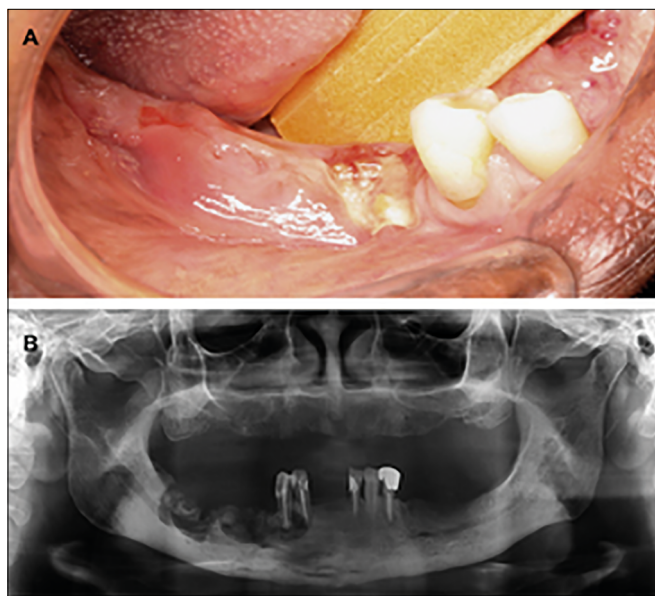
A - MRONJ clinical features showing an asymptomatic area of exposed necrotic bone on the alveolar region of the lower right premolar with no spontaneous bleeding or signs of infection. B - Initial panoramic radiography revealed the presence of diffuse sclerosis and sequestrum on the right mandibular body.
